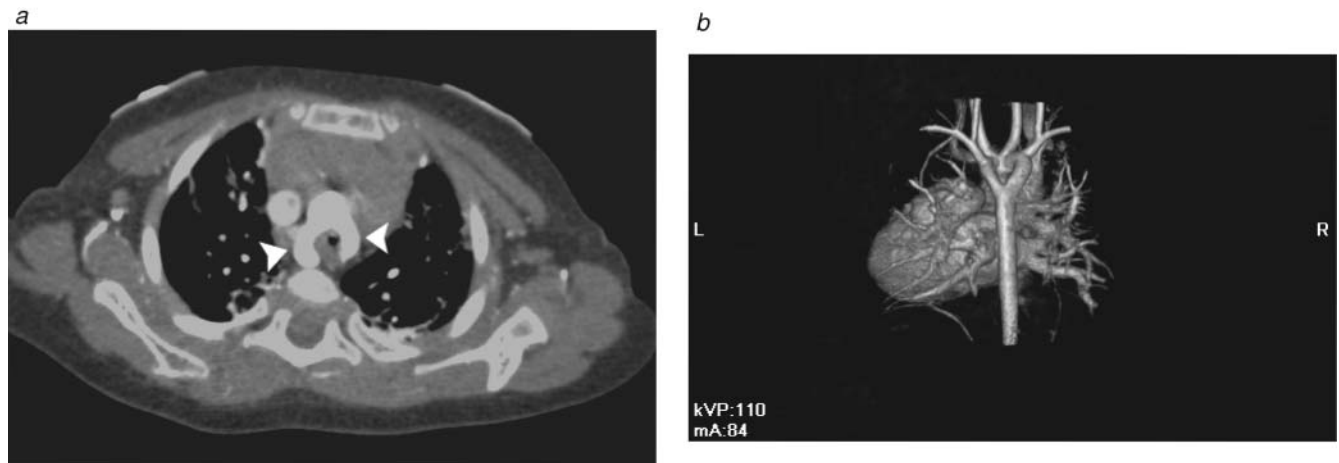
A 4-year-old male child with episodes of dyspnea and intermittent cyanosis and a widened mediastinum on a chest radiograph was referred for computed tomographic angiography. (a) Axial view from a multidetector computed tomographic angiogram shows a crescentic vascular ring (arrowheads) surrounding the trachea and esophagus. (b) A posterior coronal volume-rendered view demonstrates a complete vascular ring consistent with a double aortic arch with the right arch of larger caliber. The carotid arteries arise anteriorly from the common arch, and a subclavian artery arises from each of the right and left arches. This patient went on to have surgical correction because of the respiratory symptoms.
